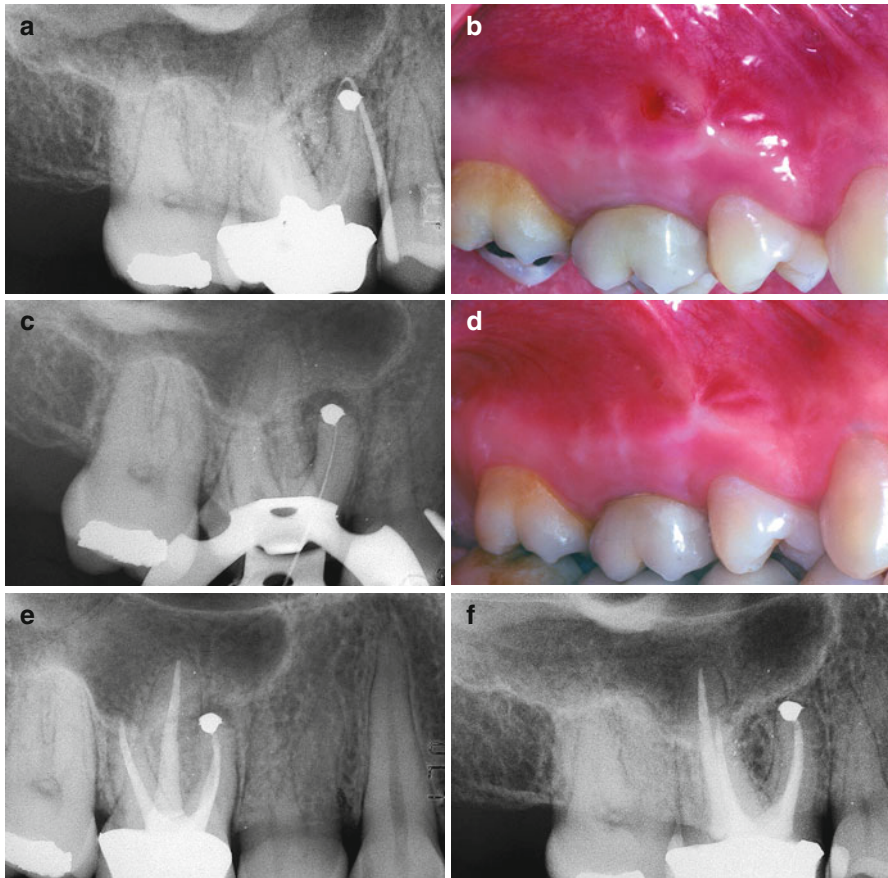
(a) Preoperative film of the maxillary right first molar. The apical surgery has been performed on contaminated and empty root canals. The surgical failure must be retreated nonsurgically. The gutta-percha cone traces the sinus tract. (b) A sinus tract is evident clinically. (c) Working length radiograph of MB1. (d) After cleaning and shaping four canals, the sinus tract disappeared. (e) Postoperative film. (f) Two-year recall
